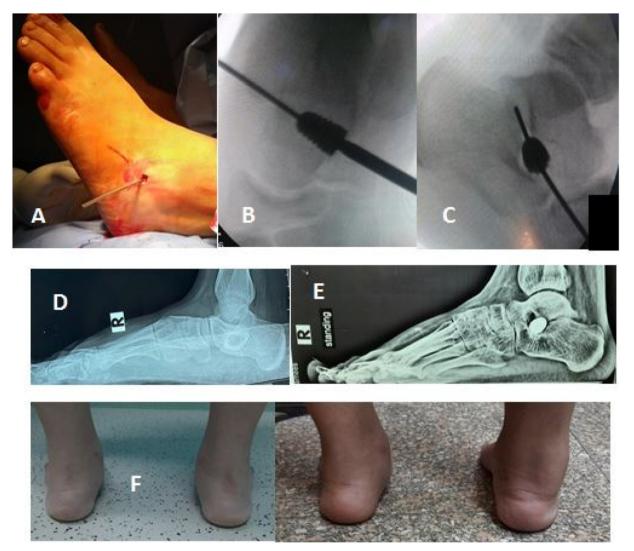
A Lateral incision for arthroereiesis B: Intraoperative fluoroscopy showing accurate implant position in anteroposterior foot view C: Intraoperative fluoroscopy showing accurate implant position in lateral ankle view. D: Preoperative ankle x ray showing c sign, loss of arch E: 3month post-operative ankle x-ray showing improvement in meary's and calcaneal pitch angle F: Pre and post clinical photo showing correction of valgus in RT side.
